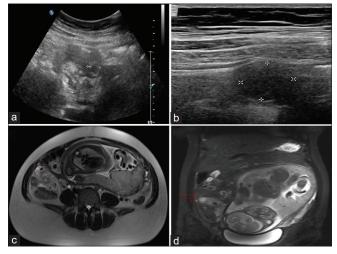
Pre-operative image. (a) Enlarged appendix seen in ultrasonography. (b) Appendicitis noticed in ultrasonography. (c) Axial image of appendicitis with appendicolith in magnetic resonance imaging. (d) Coronal image of appendicitis with appendicolith in magnetic resonance imaging
